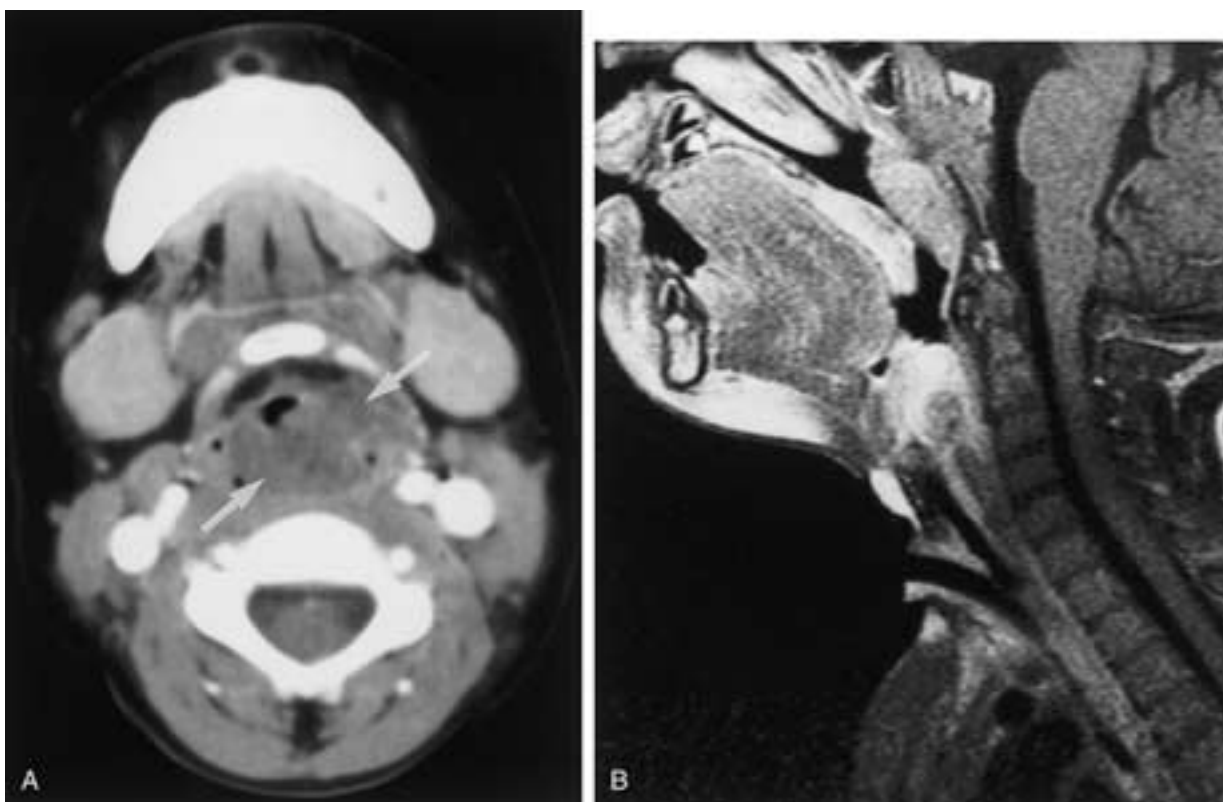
Supraglottic neurofibroma in a 2-year-old girl with neurofibromatosis type 1. A, Axial contrast-enhanced CT reveals an obstructing supraglottic mass (arrows). Since the image was acquired during the administration of contrast, enhancement of the tumor has not yet occurred. B, Sagittal contrast-enhanced T1-weighted MR image demonstrates the enhancing tumor extending between the epiglottis and the glottis. The patient has a tracheostomy tube in place.
